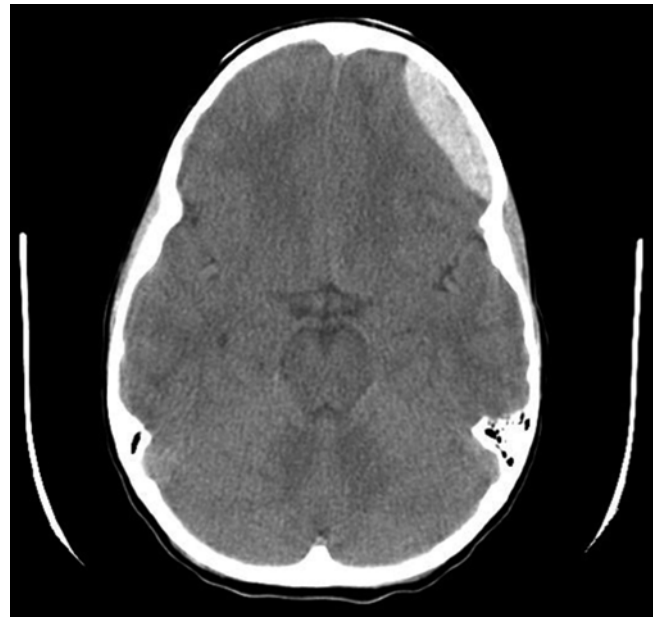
CT appearance of an epidural hematoma
